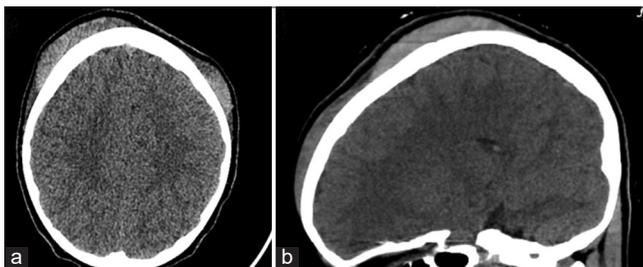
(a) Axial noncontrast CT head demonstrating bilateral subgaleal fluid collections and (b) sagittal noncontrast CT head demonstrating collections along the frontal and parietal aspects of the calvarium.
